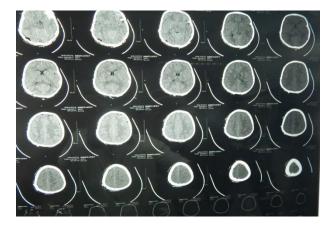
(B): Postoperative CT scan brain of case 1.
